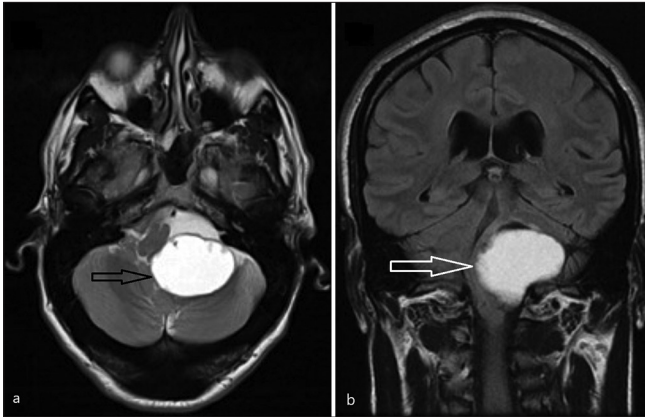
(a) Both T2-weighted images and (b) fluid-attenuated inversion recovery (FLAIR) show high signals in the lesion (arrows). At maximum dimension, the lesion measures about 46 × 31 × 42 mm.
